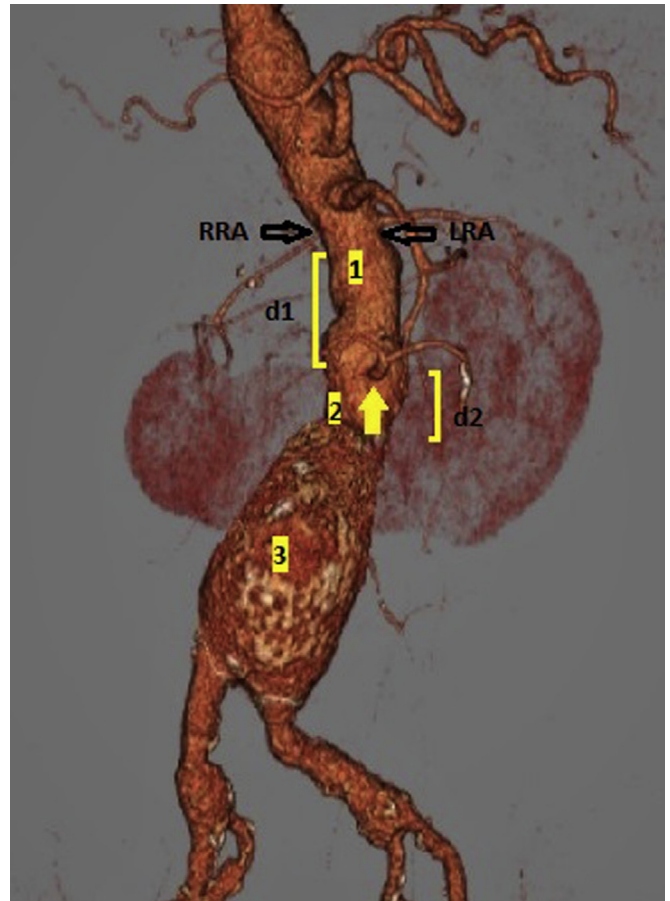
Preoperative computed tomography angiography three-dimensional reconstruction showing relationship of right renal artery (RRA), left renal artery (LRA), and mid-aortic renal artery (arrow). Centerline distance from lowest right renal artery to mid-aortic renal artery ($d1$) is 26 mm; distance from mid-aortic renal artery to proximal aneurysm sac ($d2$) is 23 mm. 1, Aortic diameter range, 25 to 28 mm. 2, Aortic diameter range, 29 to 30 mm. 3, Maximum aortic diameter, 53 mm.
